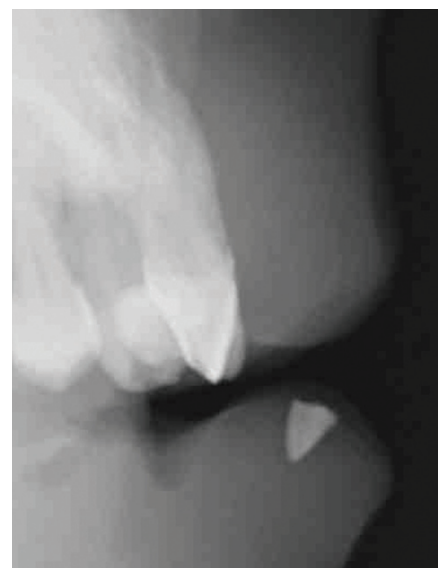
Radiograph showing a piece of tooth embedded in the lower lip
